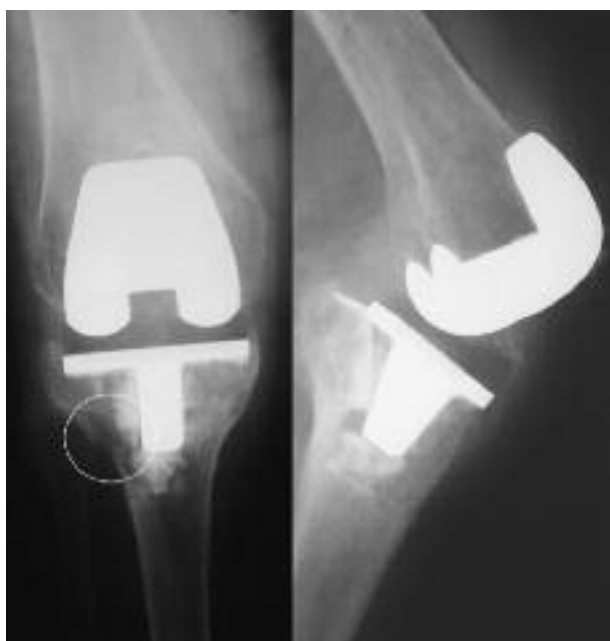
Preoperative radiographs showing tibial implant loosening. On careful inspection of the lateral tibial plateau we observe thinning of the cortical bone and cancellous bone rarefaction, suspect of malignancy.
